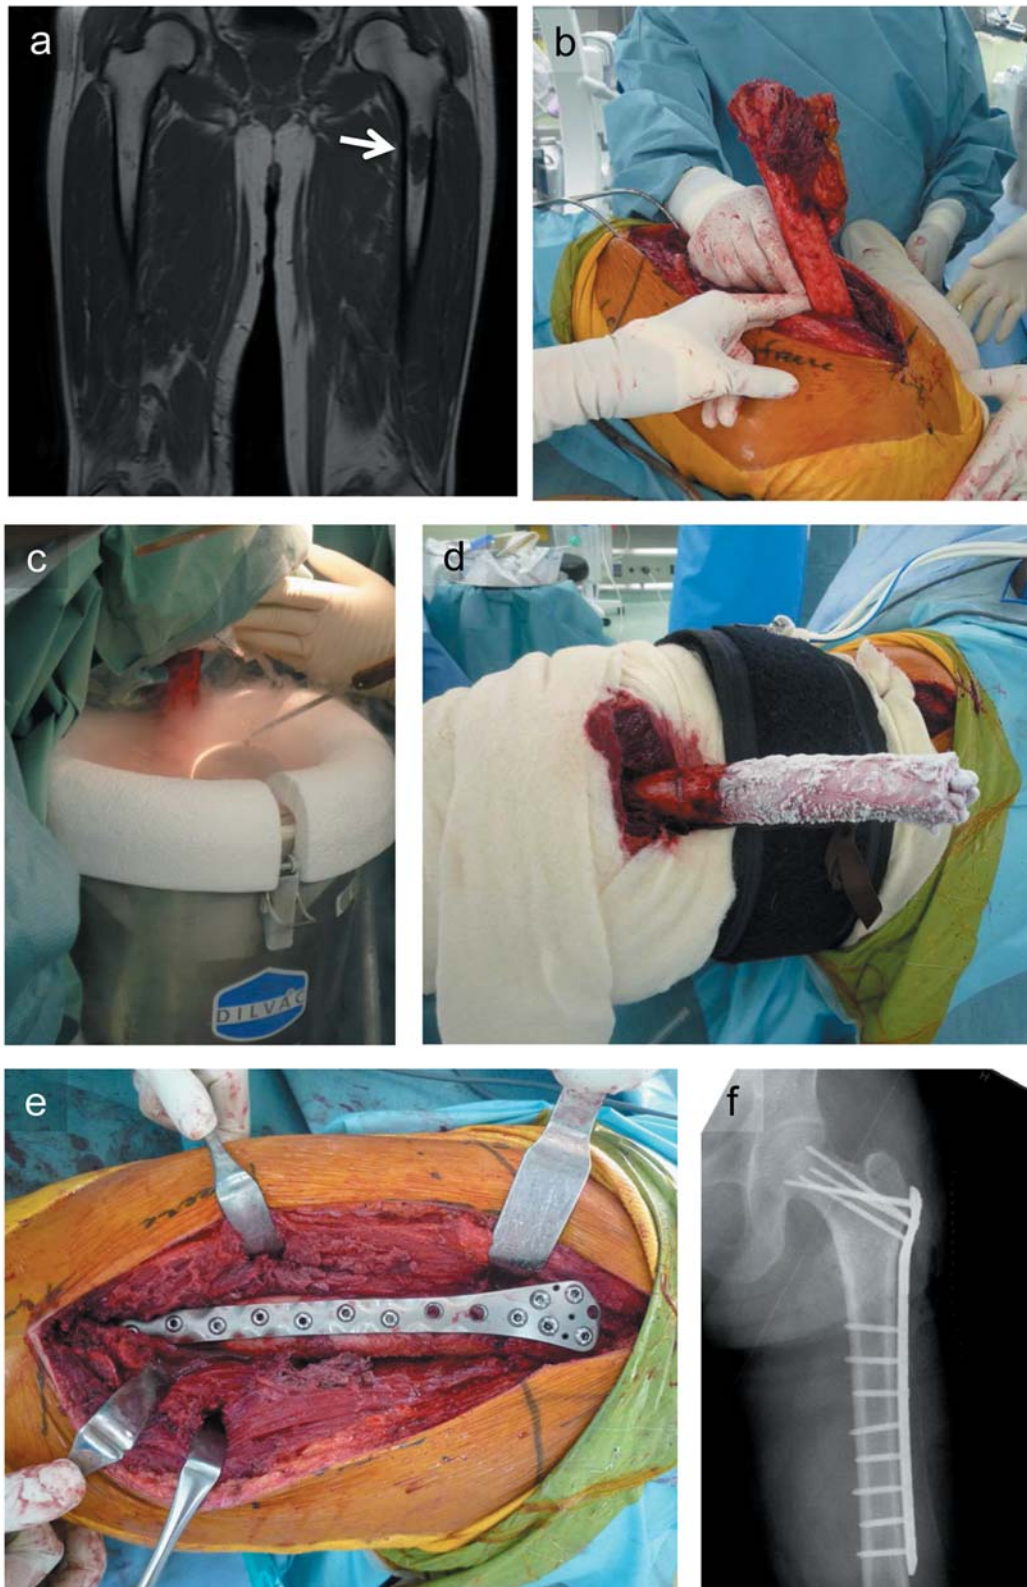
Case 10, a 55-year-old man with myxoid liposarcoma (arrow) treated by pedicle freezing. a. Preoperative MRI scan. b. One-site osteotomy and exposure of the metastatic bone. c. Pedicle freezing in liquid nitrogen. d. Thawing of the tumor-bearing frozen autograft. e. Reconstruction using plate. f. Radiograph after the reconstruction.
